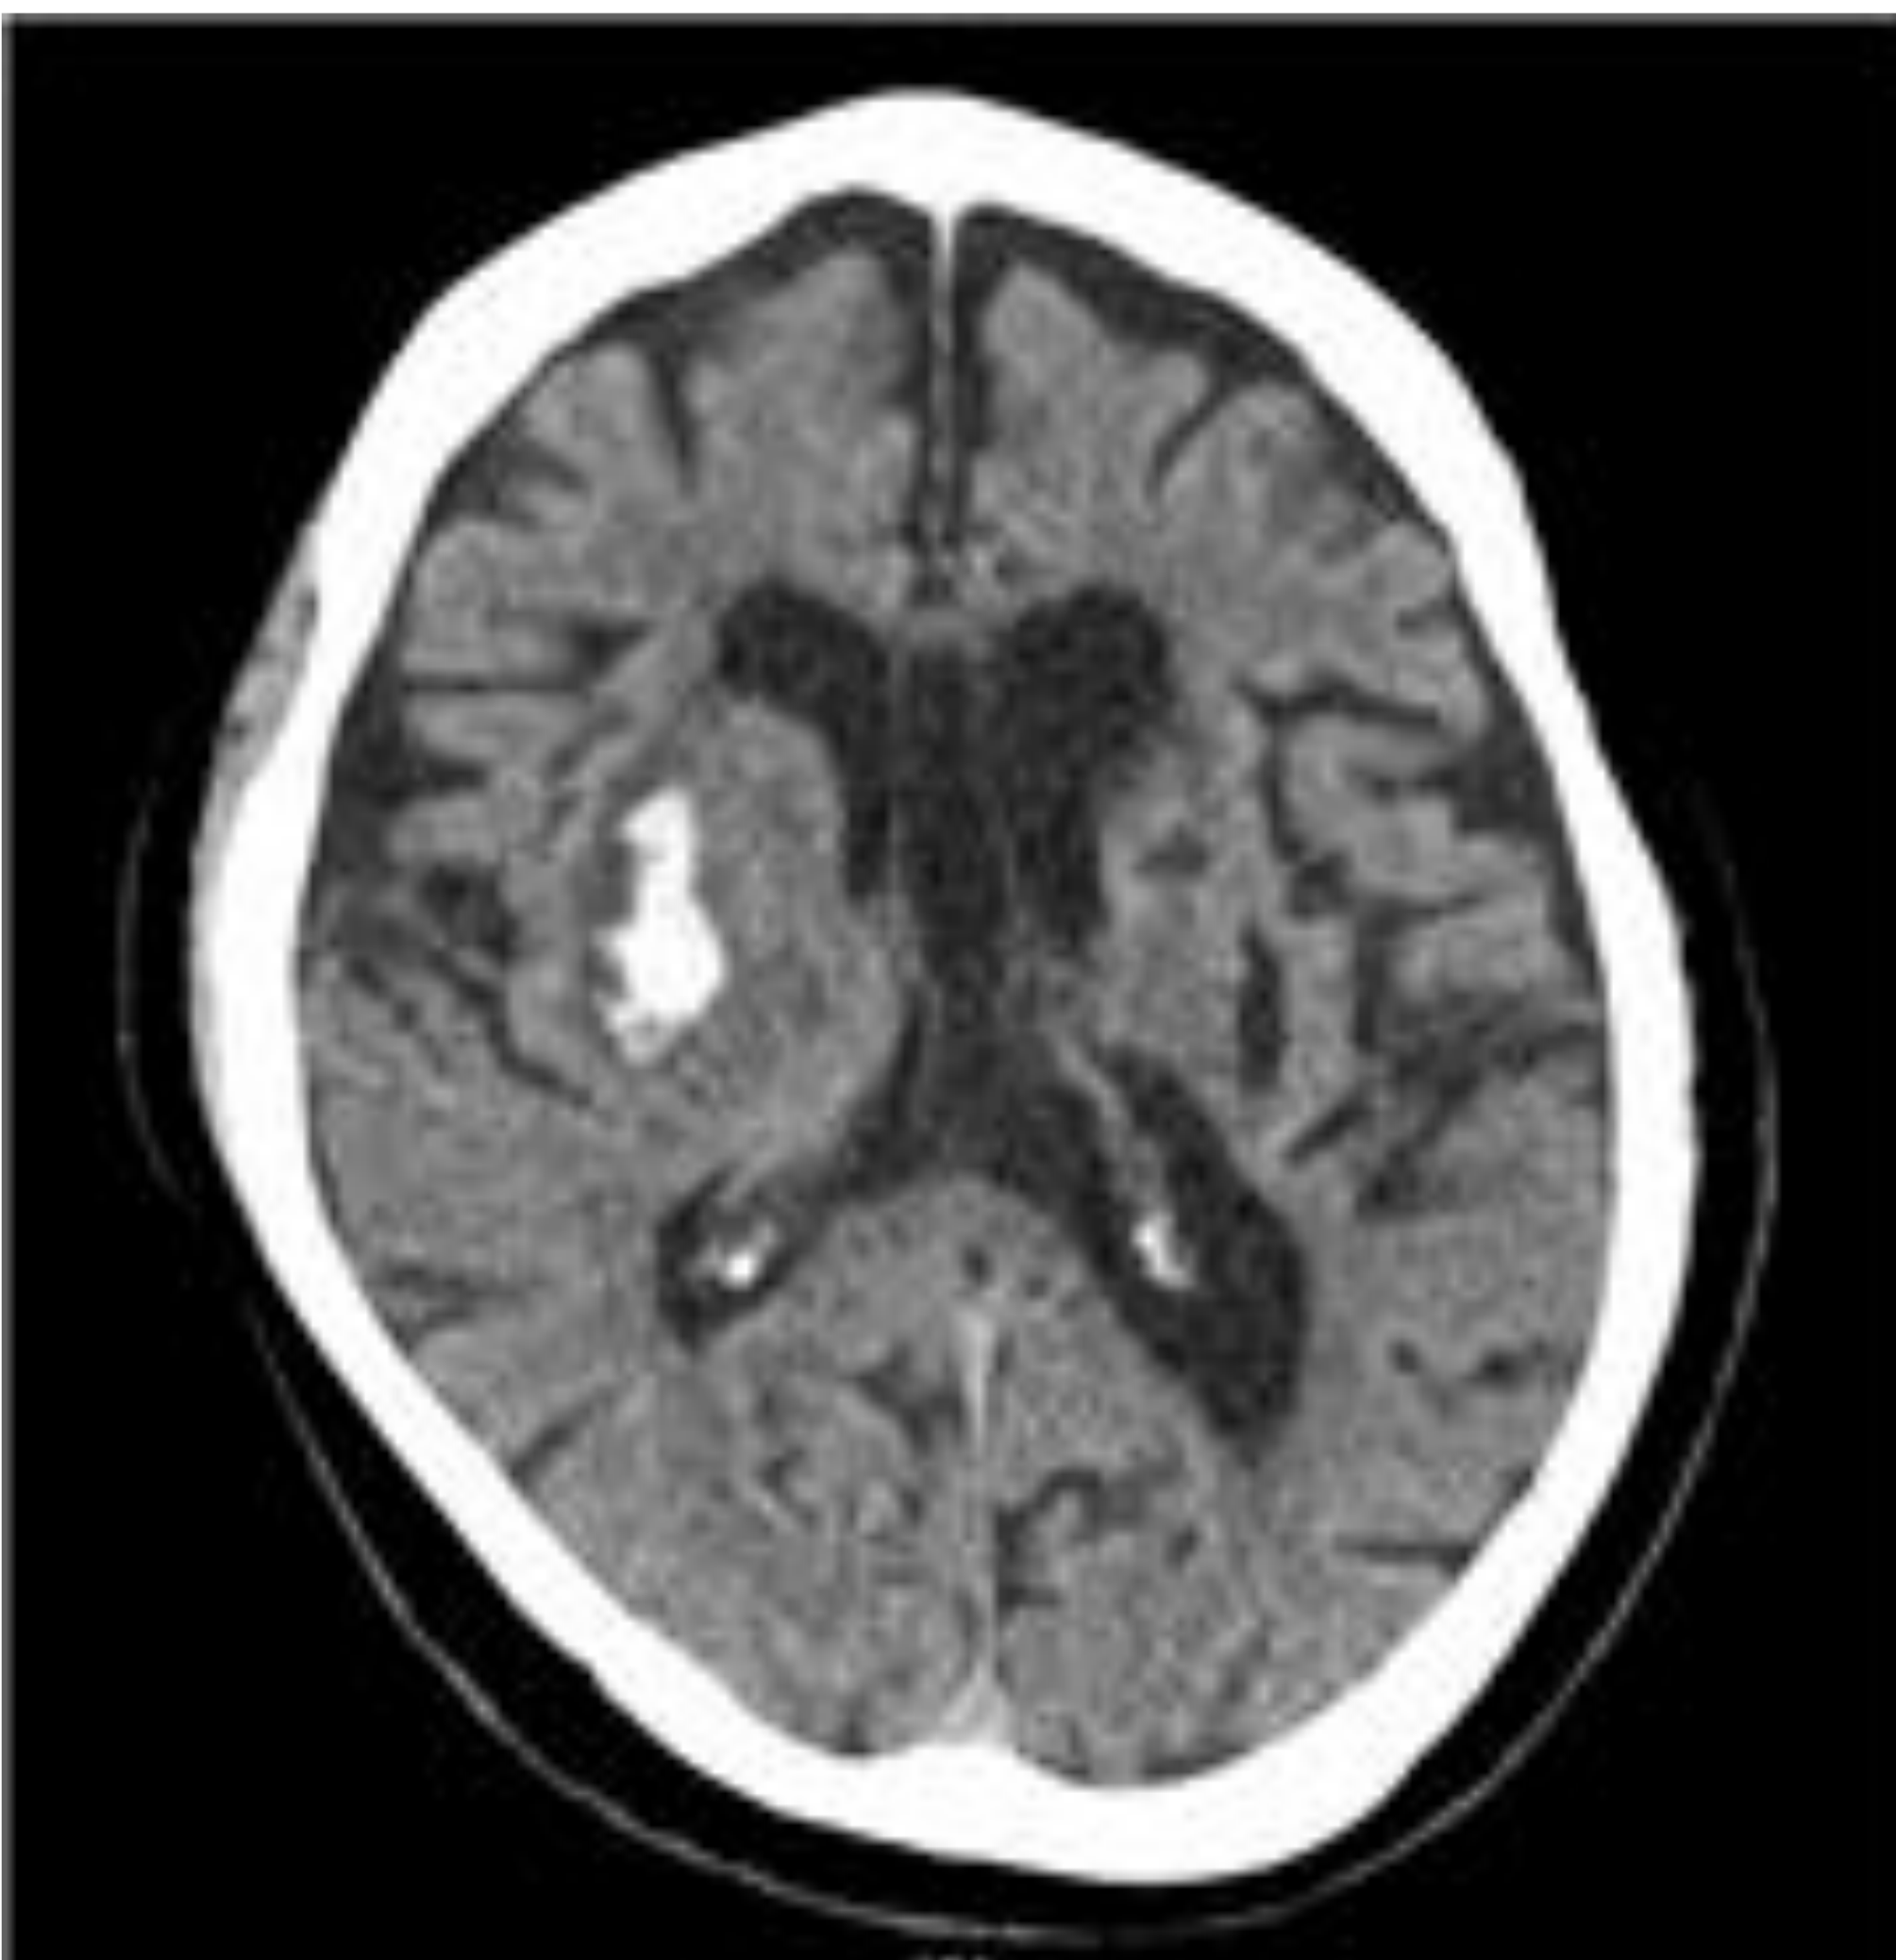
CT Brain without enhance (HD#1) : Acute ICH in right BG
